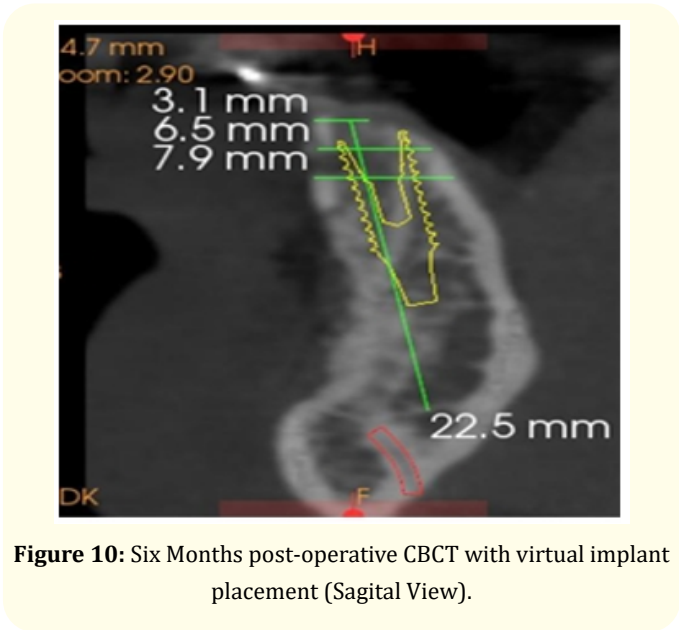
Six Months post-operative CBCT with virtual implant placement (Sagittal View).
